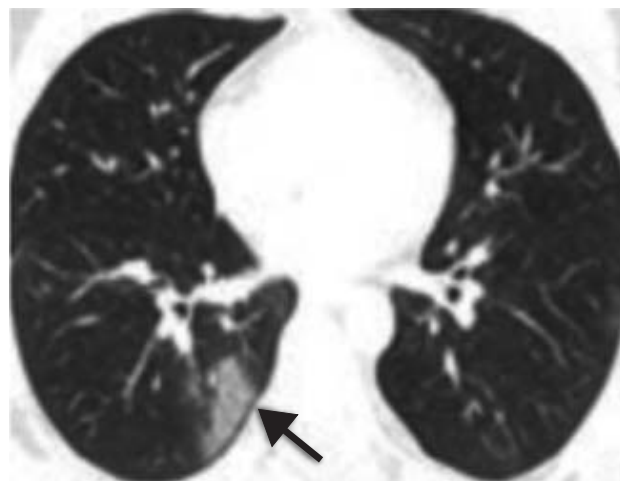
Axial chest CT image of a 27 year old male patient with positive rRT-PCR test for Covid-19, shows a patchy, subpleural ground glass opacity (GGO) in the right lower lobe associated with a thin spared subpleural space (black arrow).
